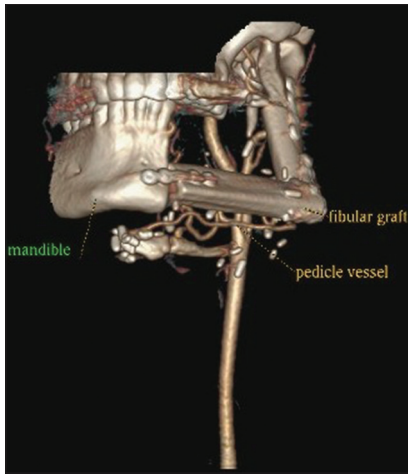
Late CT-Angio picture of the peroneal artery (Anterior view) showing the free proximal end
